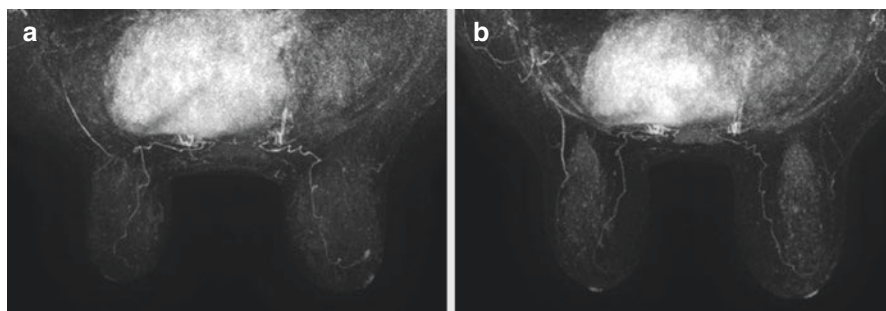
Variations in background parenchymal enhancement related to hormonal changes. These 2 images are from a screening MRI done one year apart in the same patient, at different times in her menstrual cycle. Typically there is less physiologic enhancement during days 7-14, the follicular / proliferative phase, as in (a), compared with the luteal/secretory phase as in (b)
